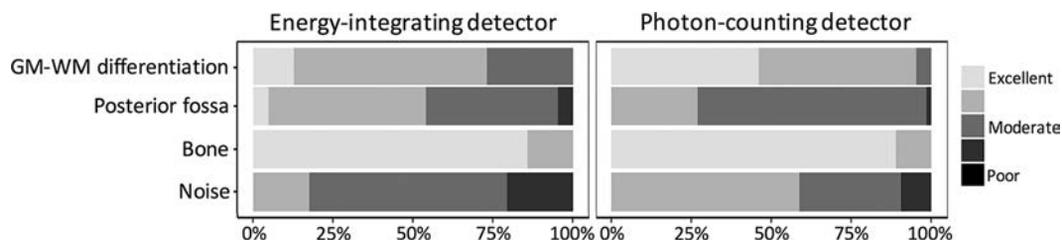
Blinded reader evaluation of image quality for energy-integrating detector and photon-counting detector head images. PCD scores are better for gray matter-versus-white matter differentiation and image noise, whereas EID scores are better for posterior fossa image quality (all $P < .001$, paired Wilcoxon signed rank test). Image quality scores are based on the European Guidelines for Image Quality Criteria for Computed Tomography.¹⁹
